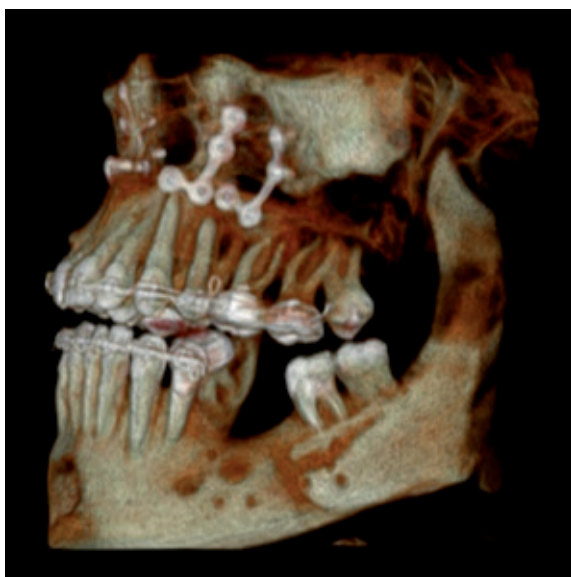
Cone-beam computer tomographic 3D reconstruction revealing osteomyelitis
